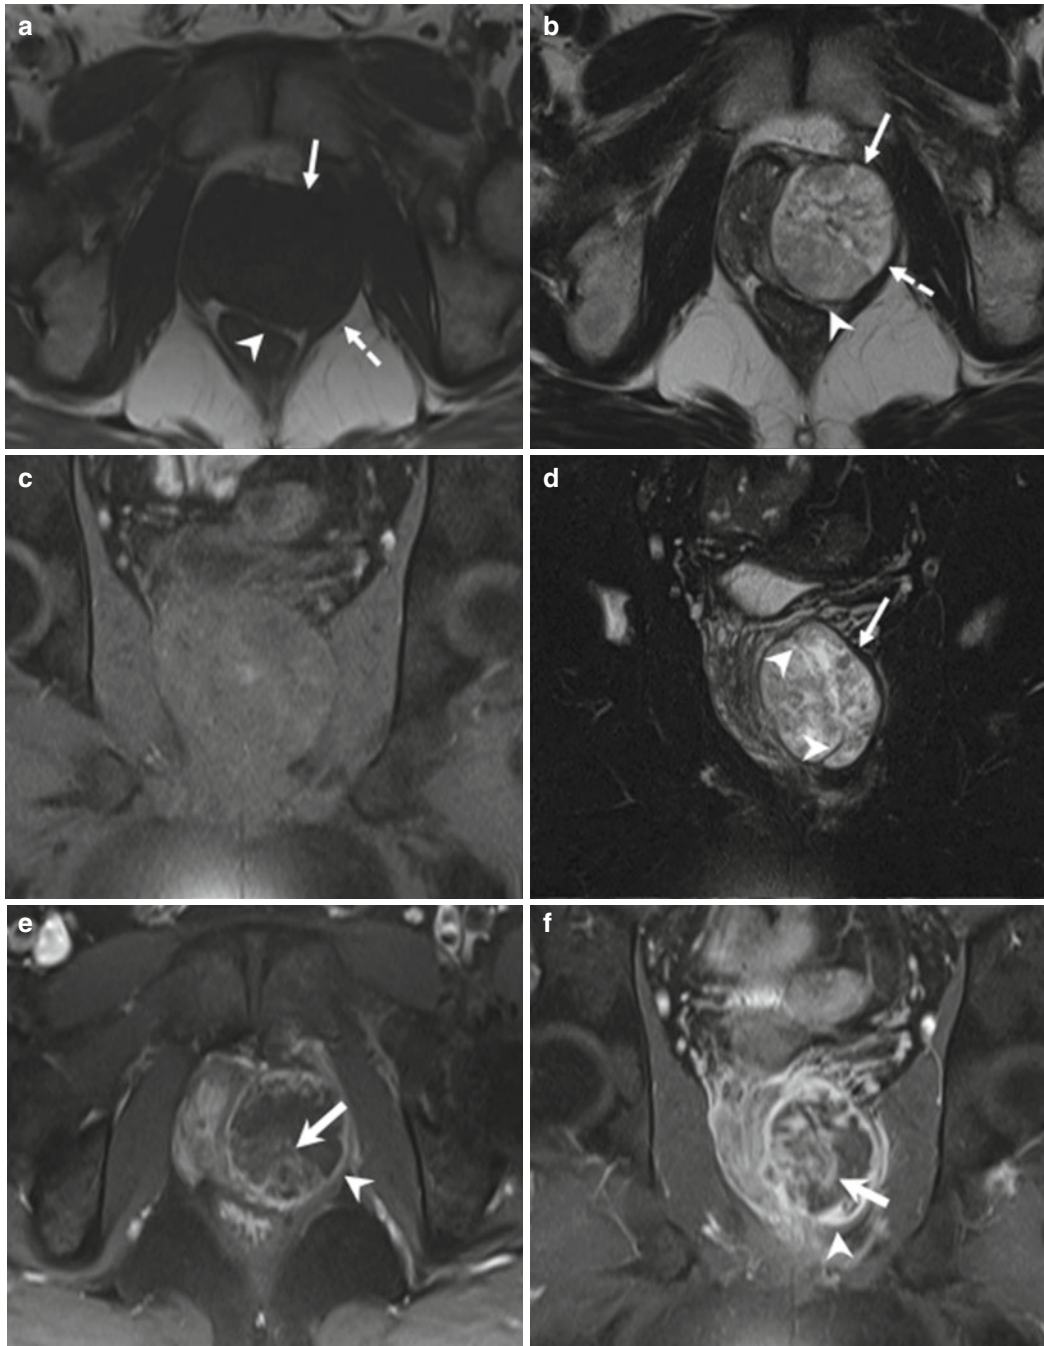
(a–f) 38 years old. Axial T1-weighted (TR: 550; TE: 9,3) sequence (a) shows the prostate increased in volume, especially the left lobes (arrow), with lateral displacement of left levator ani muscle (dashed arrow). On axial T2-weighted (TR: 5130; TE: 108) sequence (b), in the left lobe a lesion is recognizable (arrow), inhomogeneous hyperintense, with regular margins and a hypointense capsule (dashed arrow); the left lobe appears compressed and displaced to the right. Both in a and b, the posterior fat tissue is regular (arrowhead) and no sign of infiltration is appreciable. On coronal fat saturated T1-weighted (TR: 400; TE: 10) sequence (c), the lesion is
